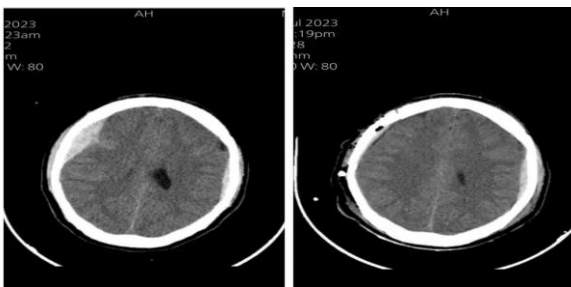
Axial CT Brain shows Frontoparietal and Parietal hematoma.
